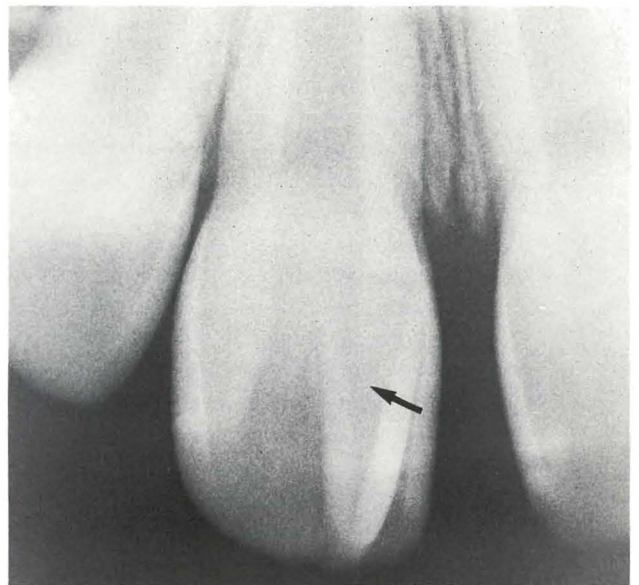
Periapical radiograph shows cusp with pulpal extension.
